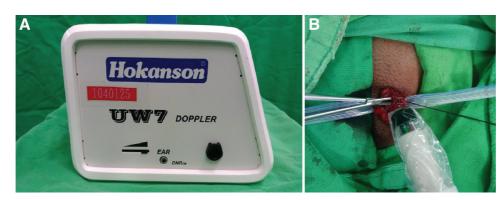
A, Vascular Doppler ultrasound. B, Ultrasound was used to identify left internal spermatic artery under the supine position.
